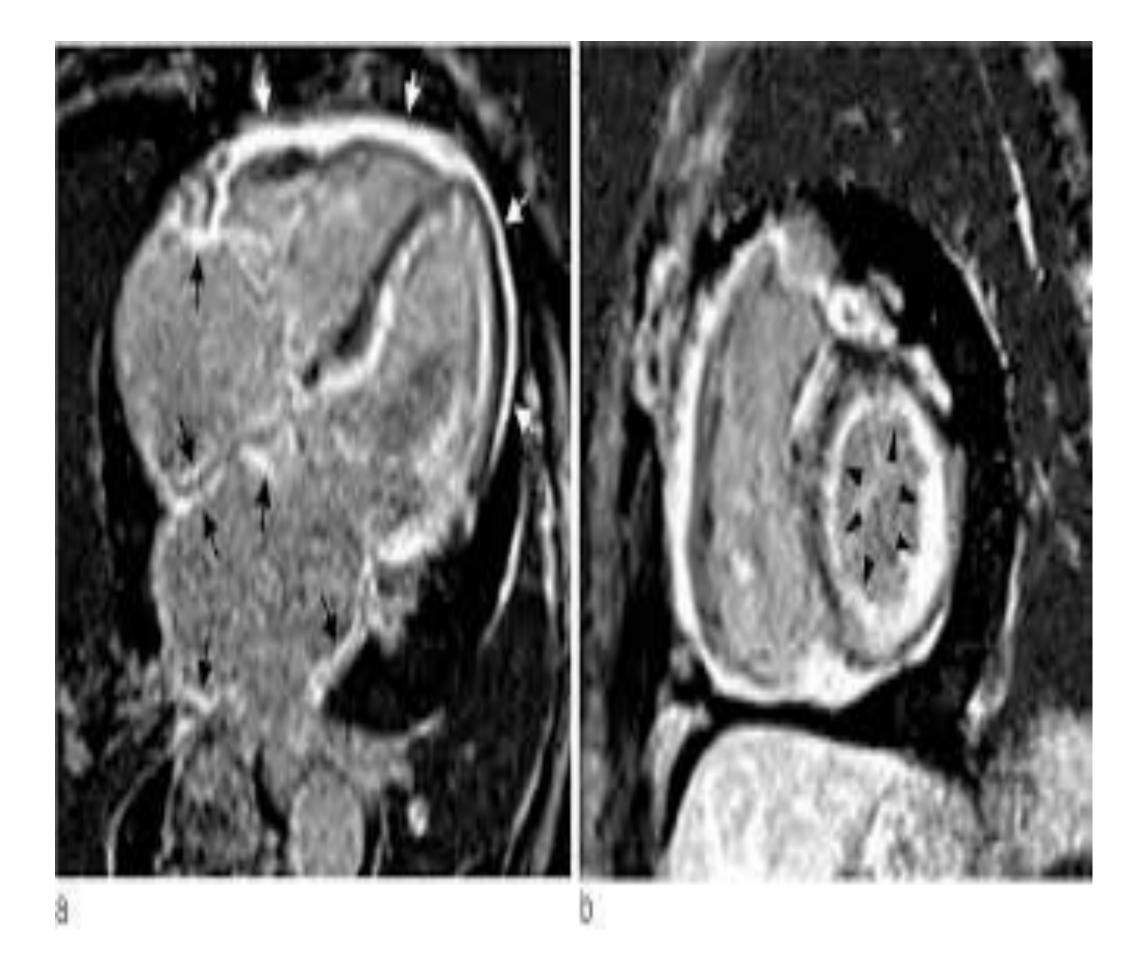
Cardiac MRI showing diffuse and irregular enhancement. Classically will have late gadolinium enhancement.
